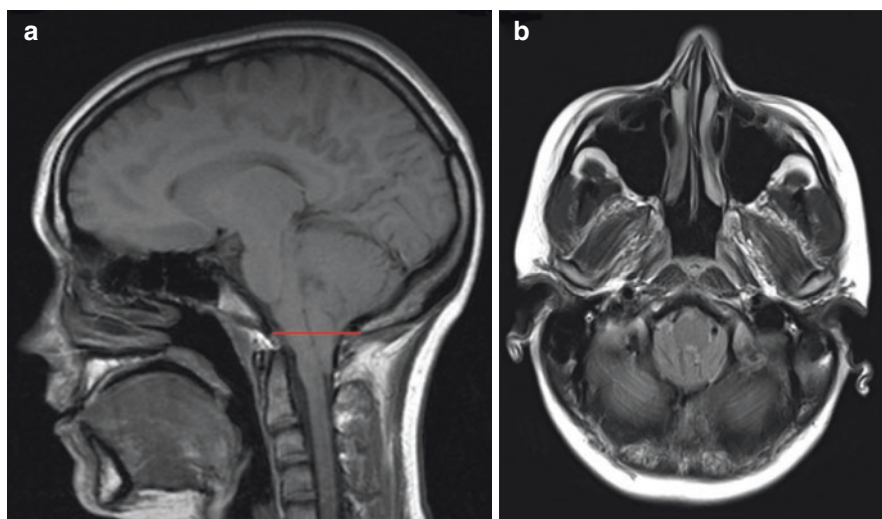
MRI scan of a 24-year-old patient with typical cough headaches. (a) Sagittal T1 sequence shows the cerebellar tonsils 18 mm below the McRae line (red) and appears “peg-like.” (b) Axial T2 sequence shows crowding at the level of the foramen magnum with reduced cerebrospinal fluid in the cisterna magna and perimedullary cisterns
